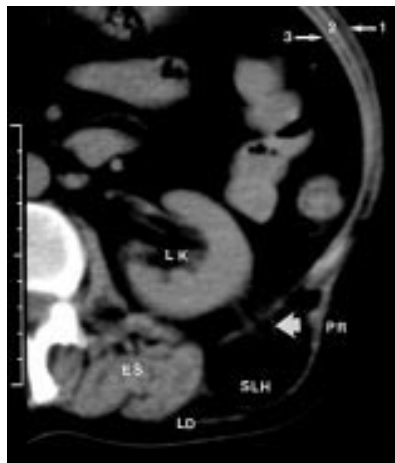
Abdominal computed tomogram showing superior lumbar hernia (SLH). LK, left kidney; PR, perirenal fat passing through transversalis aponeurosis to form SLH (arrowed); ES, erector spinae; LD, latissimus dorsi. (1) External oblique, (2) internal oblique, (3) transversus abdominis.
